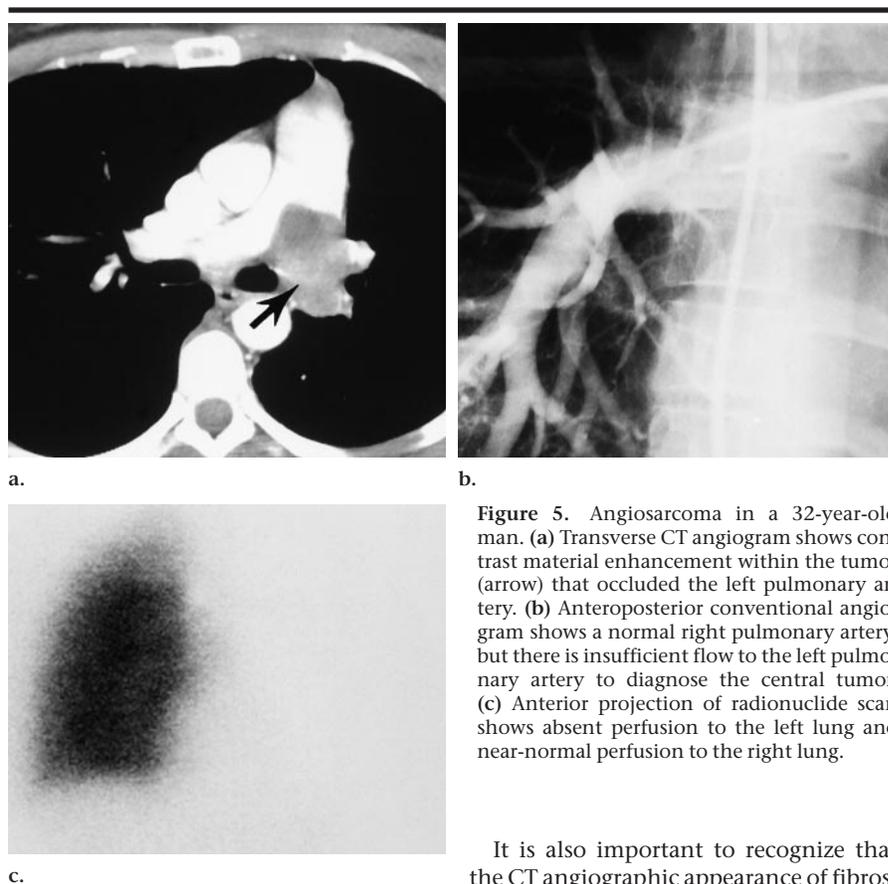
Angiosarcoma in a 32-year-old man. (a) Transverse CT angiogram shows contrast material enhancement within the tumor (arrow) that occluded the left pulmonary artery. (b) Anteroposterior conventional angiogram shows a normal right pulmonary artery, but there is insufficient flow to the left pulmonary artery to diagnose the central tumor. (c) Anterior projection of radionuclide scan shows absent perfusion to the left lung and near-normal perfusion to the right lung.
